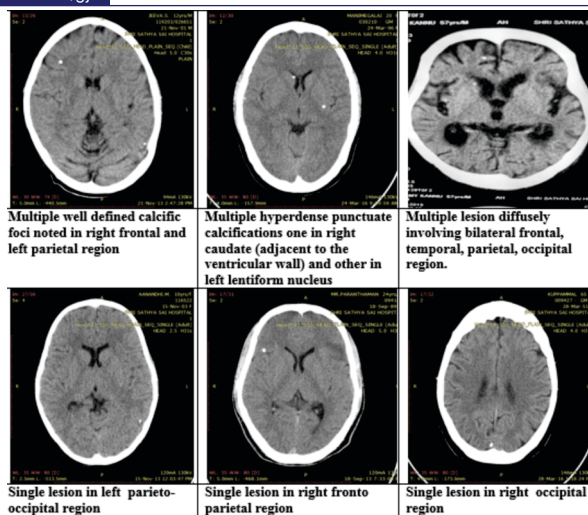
CT-Brain plain images (Multiple & Single lesions at various regions)
